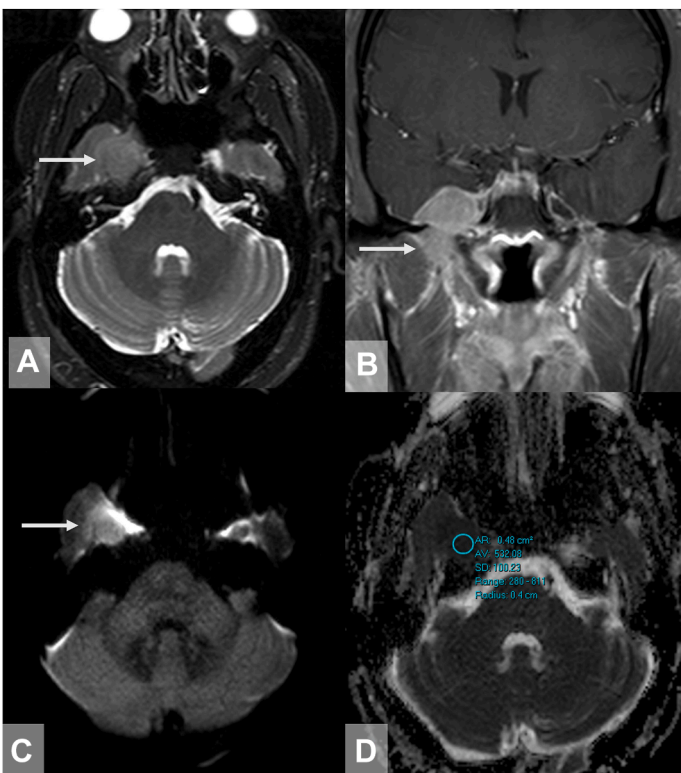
Non-Hodgkin lymphoma in the right CS as the only site of disease. Well defined, T2 isointense to cerebral cortex mass filling and expanding the right CS and Meckel's cave (A) with homogenous contrast enhancement and extension through the foramen ovale to the masticator space (B). Increased DWI signal and low ADC values (~500) are noted (C, D).
